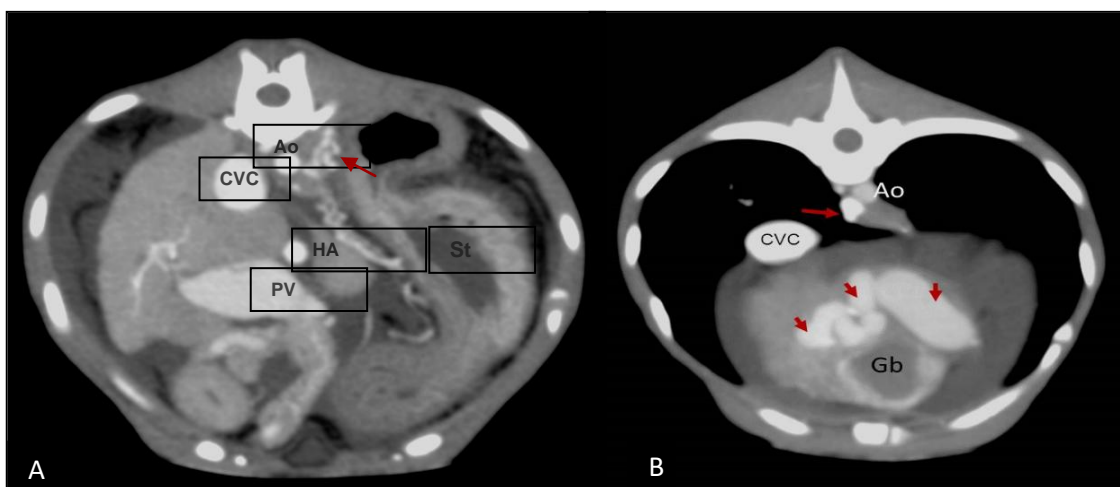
Transverse computed tomographic (CT) images of the abdomen made during the arterial phase of a dual-phase CT. A: Collateral veins are observed at lesser curvature of the stomach (arrow). The caudal vena cava (CVC), portal vein (PV) and hepatic artery (HA) are dilated. B: The entrance of the extrahepatic shunt into the dilated azygos vena (arrow). Arrowheads: dilated and tortuous portal veins in the left medial hepatic lobe. Ao: aorta; St: stomach; FF: free peritoneal fluid; Gb: gallbladder.
